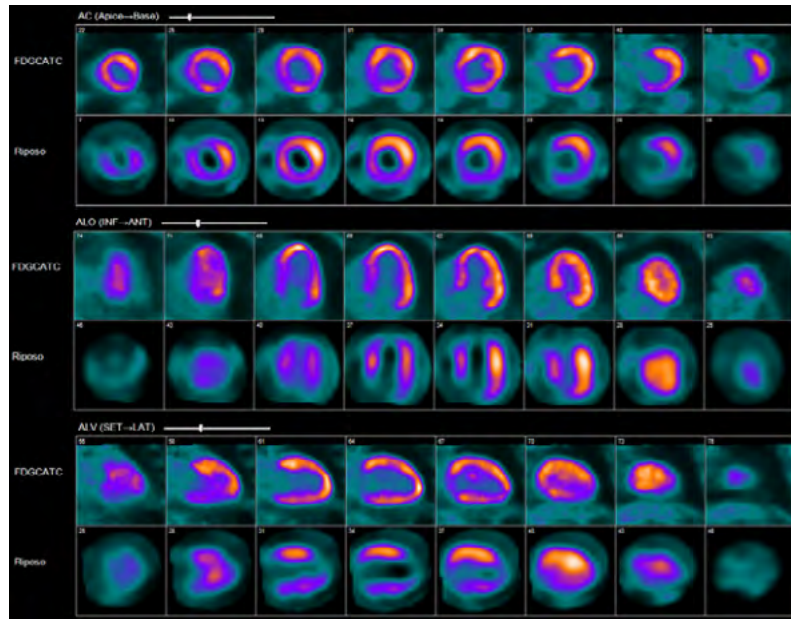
^{18}F -FDG PET myocardial viability scan showing mismatch pattern. The resting perfusion images performed with ^{99m}Tc -labelled tracer on CZT SPECT show a reduction in uptake in the anterior wall and apex (lower rows). The ^{18}F -FDG metabolism images (upper rows) show significant ^{18}F -FDG uptake in the anterior wall and apex, indicating that there is significant perfusion-metabolism mismatch, or hibernating myocardium in these regions.
